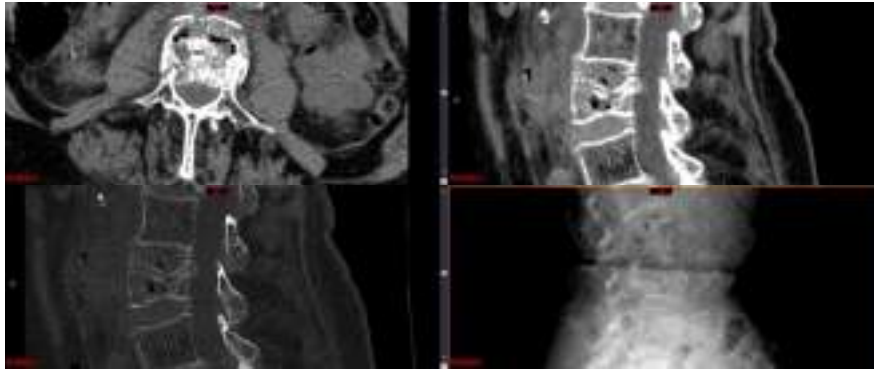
Example of computed tomography images and plain radiography used as learning paradigm for spinal anatomy teaching using the advanced Carestream viewer (Philips®).
